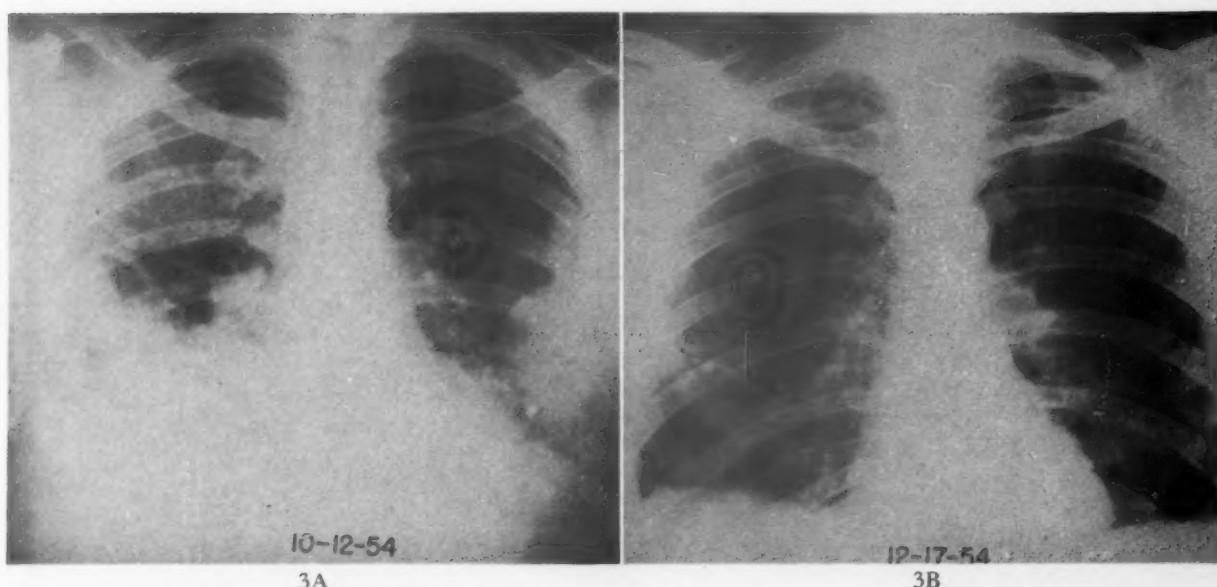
Serial x-ray studies of the chest in patient showing the appearance and clearing of multiple pulmonary infarctions.
